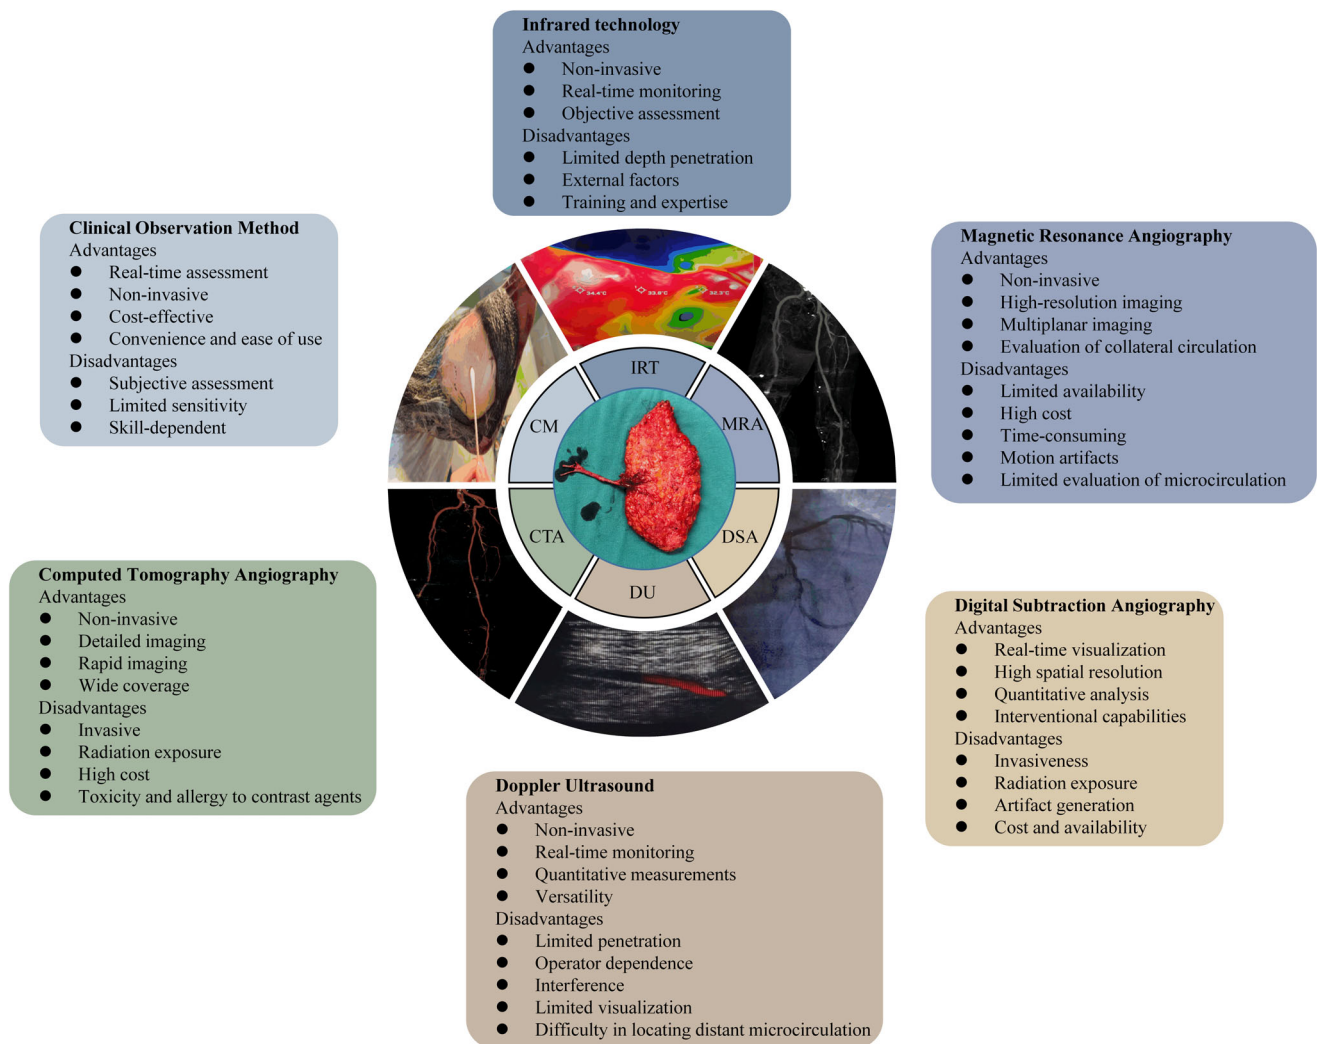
Comparison of Blood Supply Monitoring Methods for Flaps: The figure showed a comparison of different methods, including IRT (infrared thermography), MRA (Magnetic Resonance Angiography), DSA (digital subtraction angiography), DU (duplex ultrasonography), CTA (computed tomography angiography), and CM (clinical observation), for monitoring blood supply in flaps. Each method's advantages and disadvantages were indicated, providing a comprehensive evaluation of blood supply monitoring techniques.
